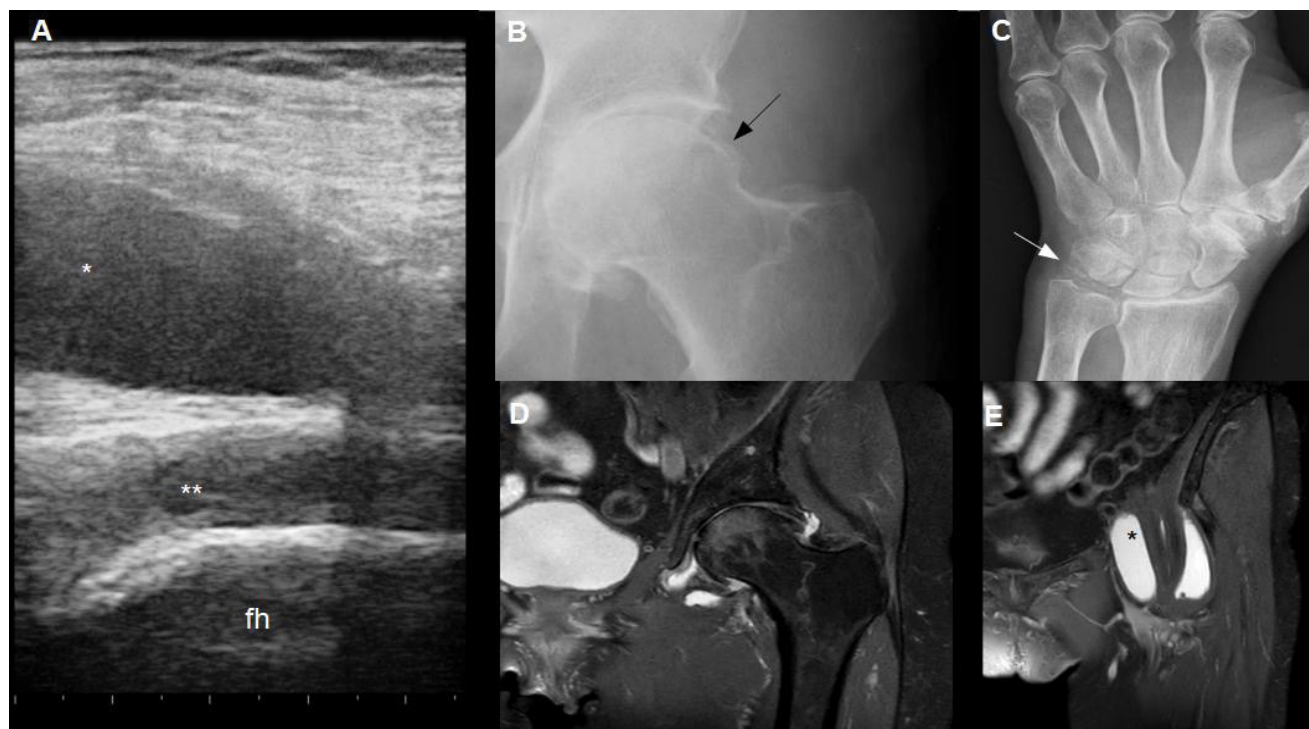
Anterior Hip Longitudinal Ultrasonography scan (A) showing fluid effusion (*) anterior to left coxo-femoral joint (femoral head, fh) and coxo-femoral synovial hypertrophy (); X-ray of (B) both left coxo-femoral and (C) radiocarpal joints showing calcifications of the soft tissues near the left hip (black arrow) and radiocarpal (white arrow) joints suggestive of calcium pyrophosphate crystal deposition; Magnetic Resonance Imaging: STIR sequenced coronal image of coxo-femoral joints and pelvic area evidencing osteoarthritis and mild joint effusion (D), and STIR sequenced coronal image of the iliopsoas bursa (E).
